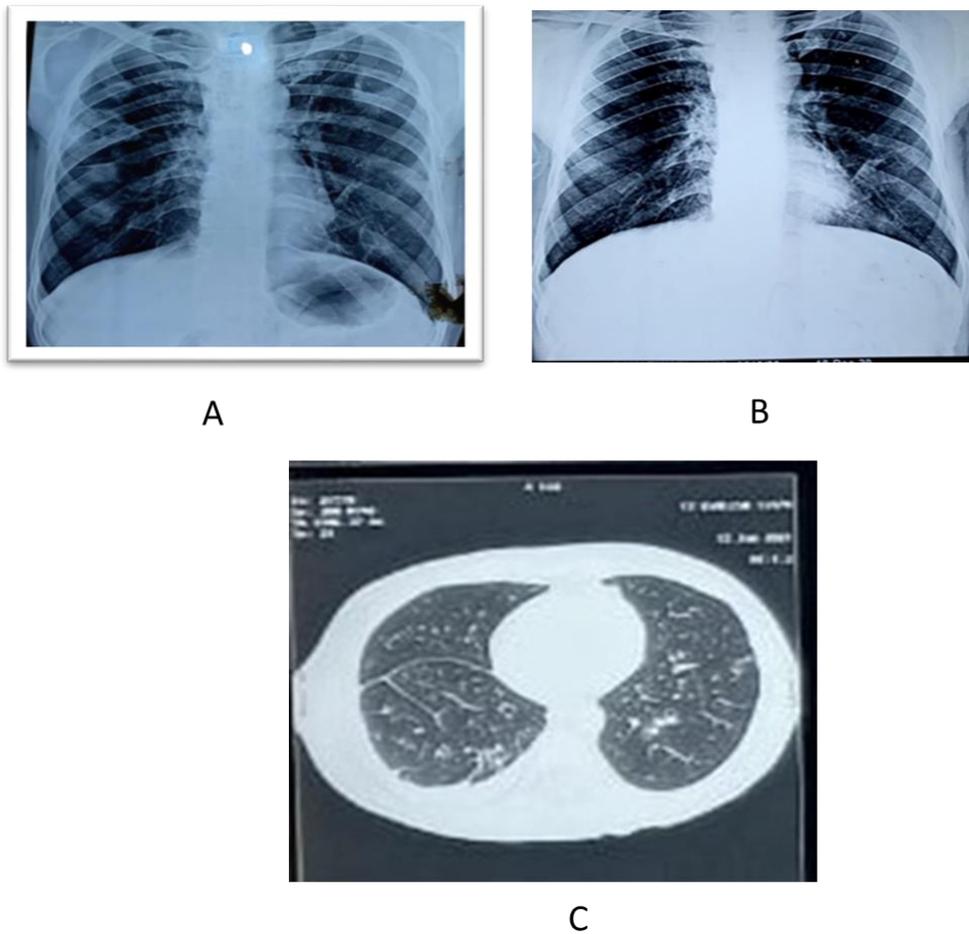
A-Pre-covid X-Ray chest (PA) status; B- Post-covid X-Ray chest (PA) status and C- Post-covid CECT scan chest status
